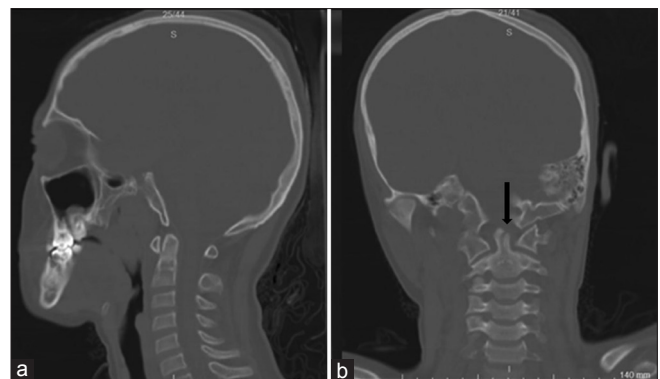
(a) While sagittal reconstruction of cervical CT was normal (b) Coronal reconstruction demonstrated vertical odontoid fracture clearly (black arrow)
